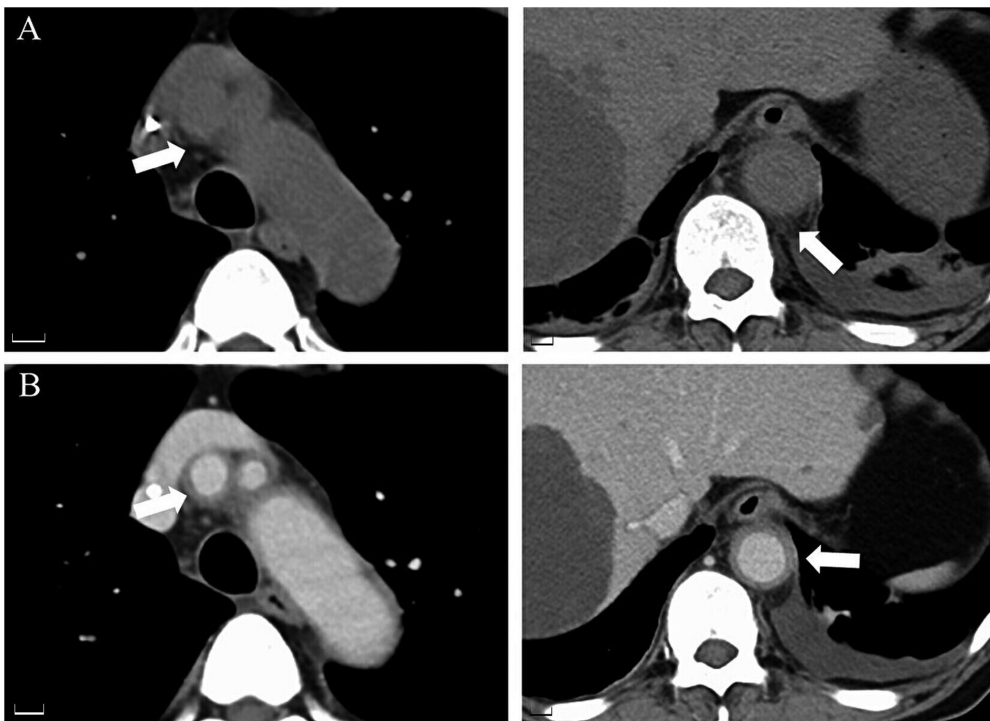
CT scan findings. Scale bars, 1 cm. (A) Non-contrast CT showed periaortic soft tissue inflammation around the brachiocephalic artery (left) and abdominal aorta (right). (B) Contrast-enhanced CT showed thickening of the walls of the brachiocephalic artery (left) and abdominal aorta (right). CT, computed tomography.
